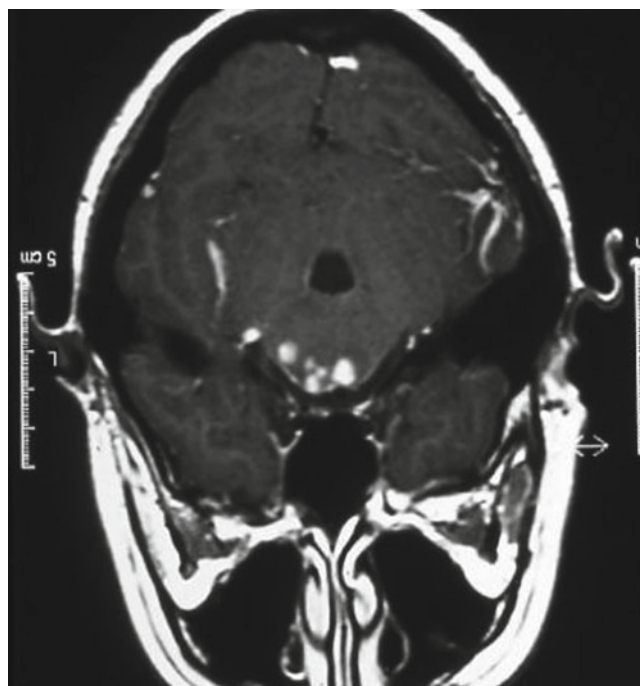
MRI scan of a woman with isolated central nervous system histoplasmosis. The scan shows meningeal enhancement as well as several enhancing lesions in the midbrain
